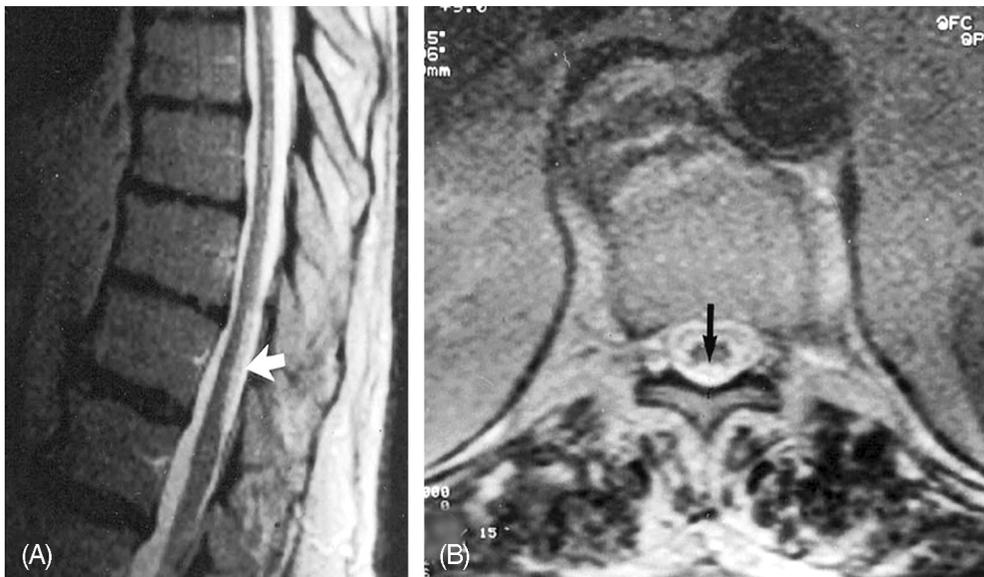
Infarction in the territory of the posterior spinal artery. (A) Sagittal T2-weighted (4500/120/6) fast spin-echo image obtained 4 months after endovascular therapy shows sharply defined elongated high signal intensity of the posterior spinal cord (arrow) at T10–11. (B) Axial T2-weighted (5000/120/6) fast spin-echo images show sharply defined signal changes (arrow) involving the posterior columns at T11. Reproduced from Mascalchi et al., 1998 with permission. © American Society of Neuroradiology.
